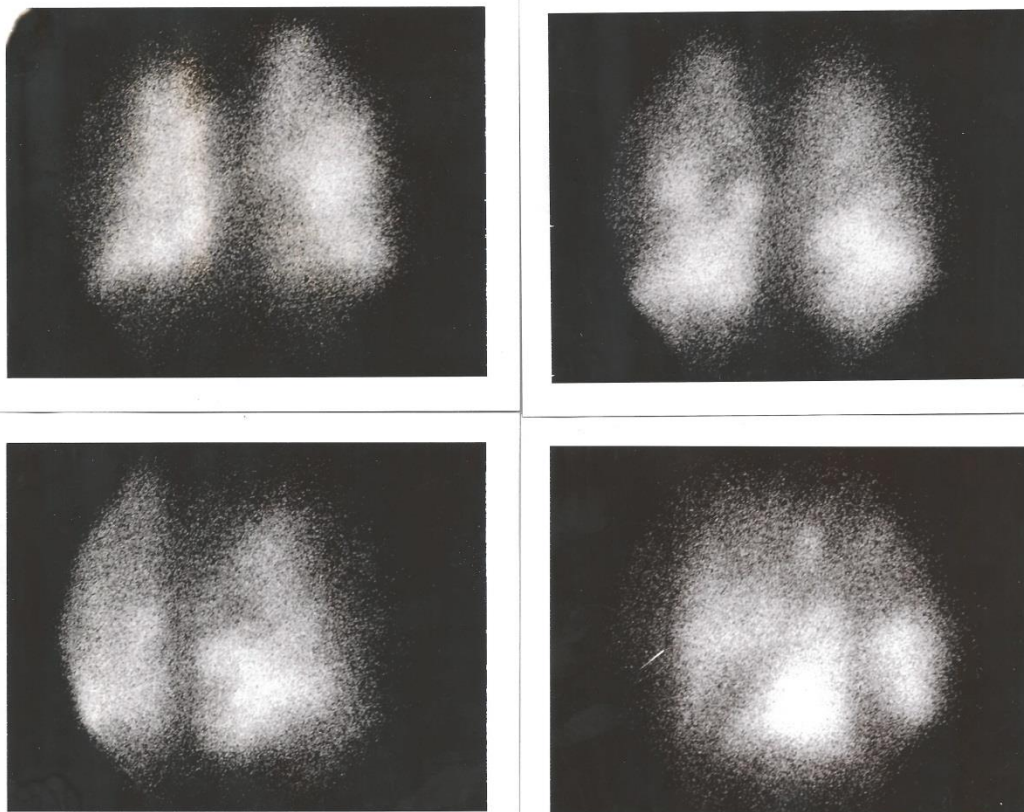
Perfusion scintigraphy of a 49 year old man in front, posterior, right-posterior semi-oblique and left-posterior semi-oblique projections with multiple metastases in both lungs from carcinoma with unknown primary focus.
